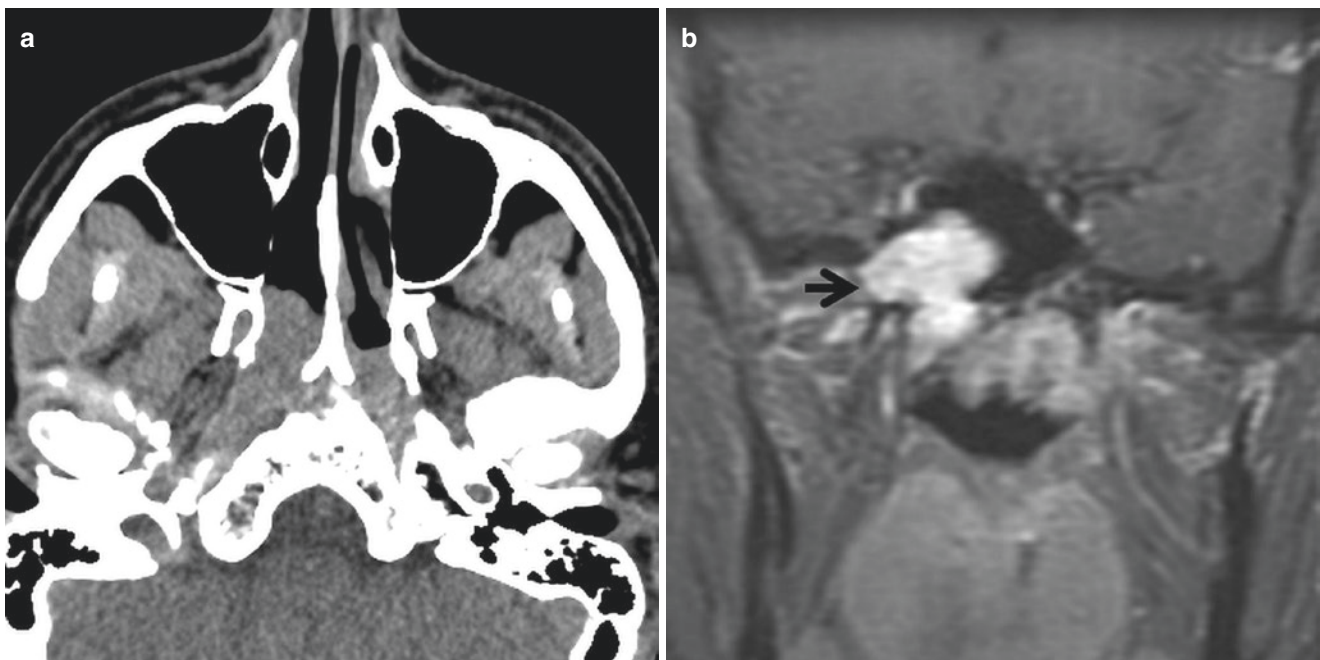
Juvenile nasopharyngeal angiofibroma. A 9-year-old with recurrent epistaxis. (a) Axial CT shows a soft tissue mass in the right nasopharynx. (b) Postcontrast coronal MRI demonstrates an avidly enhancing mass in the right sphenoid sinus and nasopharynx extending
